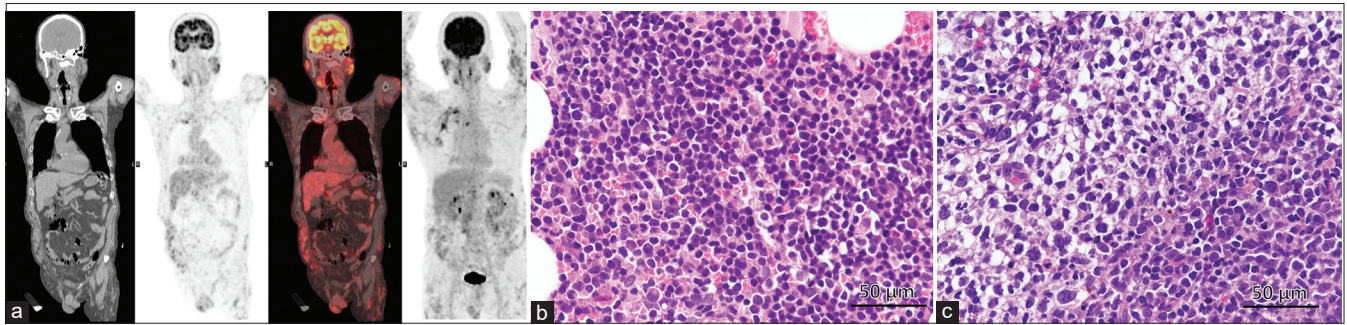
(a) Positron emission tomography-computed tomography revealed diffused numerous lesions and lymph nodes with fluorodeoxyglucose uptake malignancy. (b) Multiple aggregations of small to medium size atypical lymphoid cells with hyperchromasia and irregular nuclear membrane (c) Infiltration of small to large size atypical lymphoid cells with focal clear cytoplasm, prominent nucleoli, and irregular nuclear membrane
